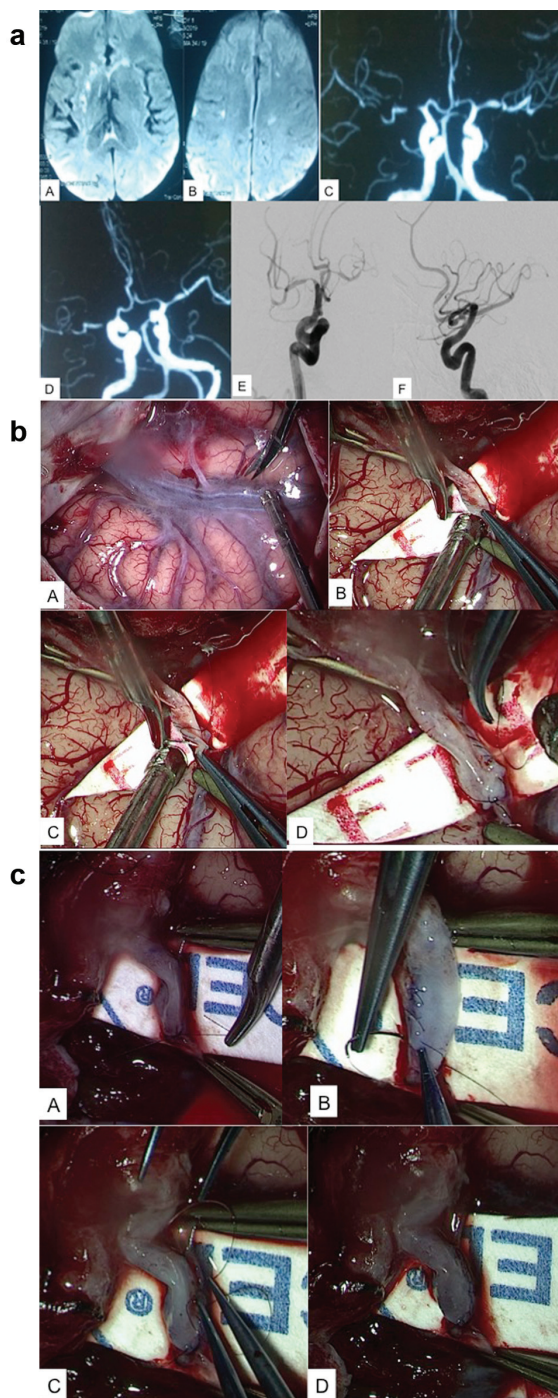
(a) (A and B) MRI of the brain DW images showing the right MCA territory and left ACA ischemia and patchy infarcts. (C and D) CTA of the brain showing right M1 stenosis (severe) and left A2 stenosis. (E and F) Cerebral DSA showing right M1 stenosis (severe) and left A2 stenosis. (b): (A, B, C, and D) Preoperative pictures of anastomosis for temporal STA-MCA bypass as a part of double barrel bypass. (c) (A, B, C, and D) Preoperative pictures of anastomosis for frontal STA-MCA bypass as a part of double barrel bypass. (d): (A, B, C, and D) Preoperative sequential picture of A3-A3 bypass in the frontal interhemispheric fissure; (A and B) Durotomy and interhemispheric dissection. (C and D) Identification and preparation of left and right A3 after removal of a small part of the falx. (e): (A, B, C, and D) Preoperative sequential pictures of A3-A3 side to side anastomosis. (f) (A and B) Postoperative CTA of the brain showing patent double barrel STA-MCA bypass and A3-A3 bypass (yellow circles indicate anastomosis). Privacy Policy | Disclaimer | Site Map.
